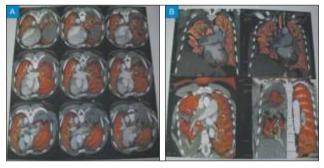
CT pulmonary angiogram showing large filling defect in the right main pulmonary artery extending into the lower lobe arteries with infarction/consolidation of right lower lobe. It also evidenced dilated right atrium and right ventricle with minimal right sided pleural effusion.
